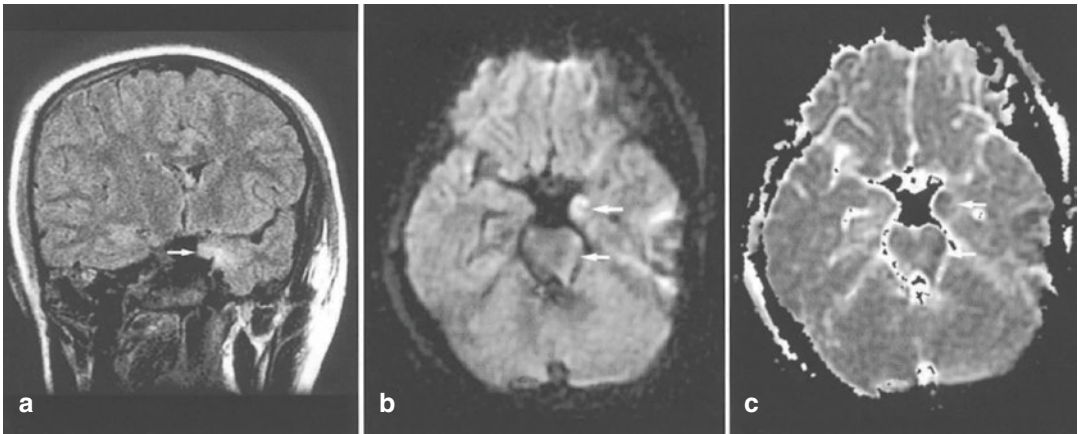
(a–c) Brain contusion in the hippocampus in an 11-year-old girl after a motor vehicle accident. (a) FLAIR image shows a hyperintense lesion in the left hippocampus (*arrow*). (b) DW image shows this lesion as
